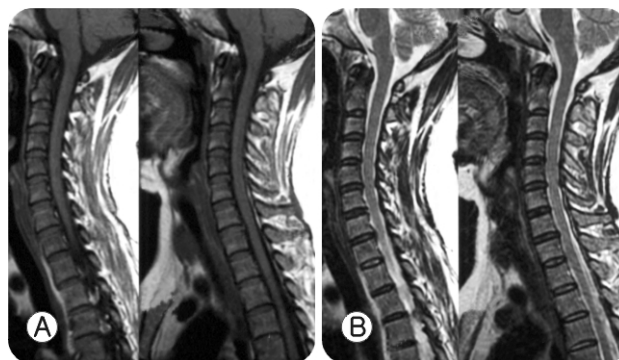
Magnetic resonance imaging of the cervical spine showed stenotic, degenerative changes without evidences of traumatic lesions.
